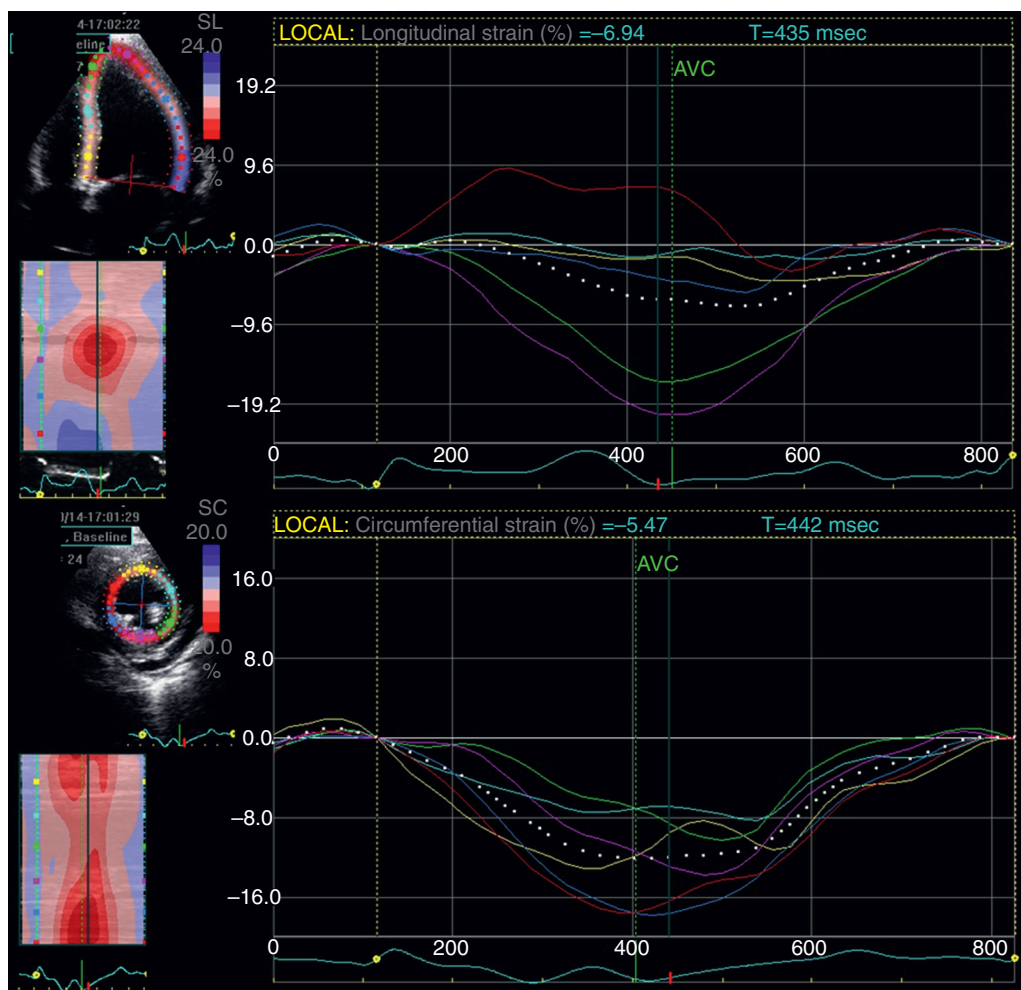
Speckle-tracking echocardiography–based measurement of left ventricular longitudinal strain (upper panel) and circumferential strain (lower panel). Colored traces depict segmental strain for corresponding myocardial segments. The dotted white line depicts the average of the six segments visualized in the particular view. AVC, Aortic valve closure.
